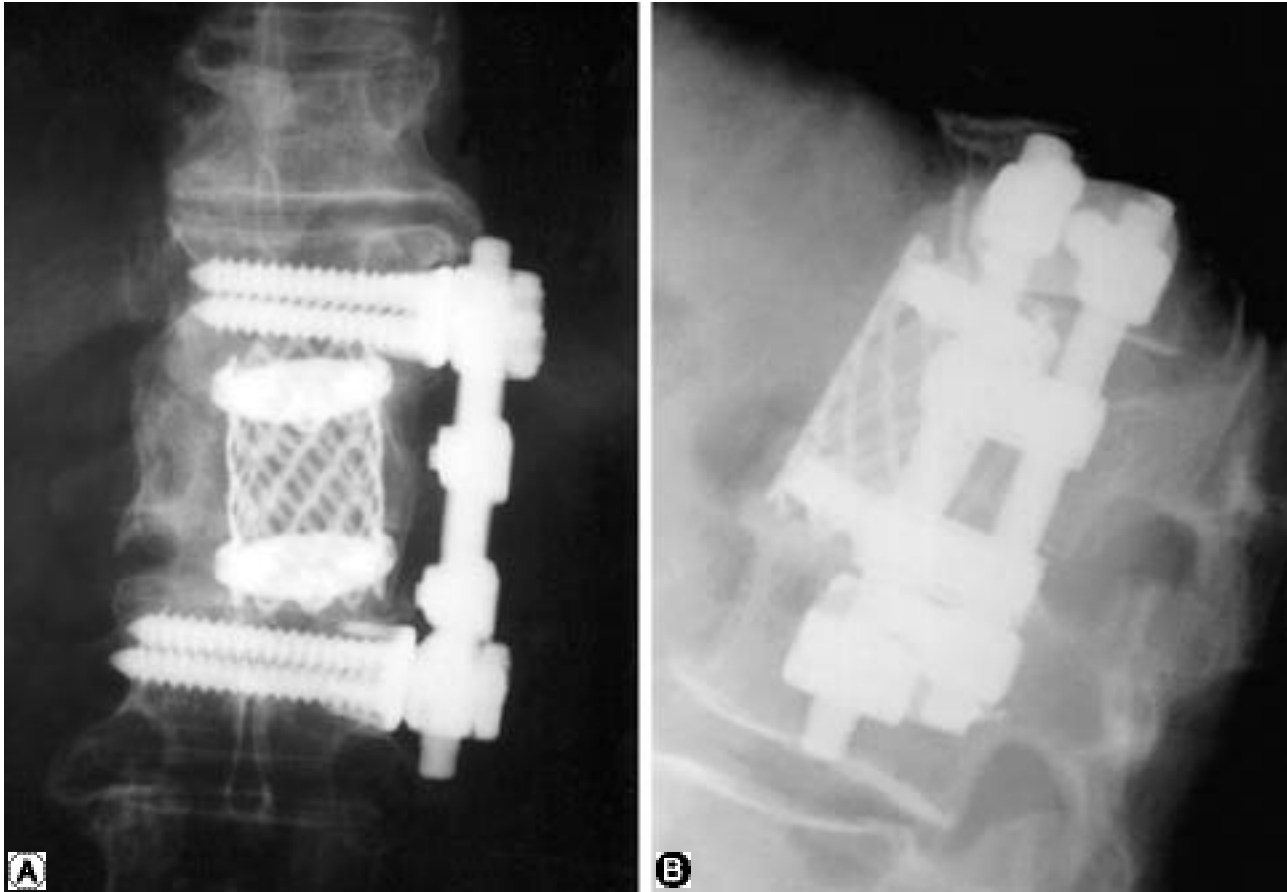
Radiographs at 17 months after operation demonstrates good union with correction of deformity.
